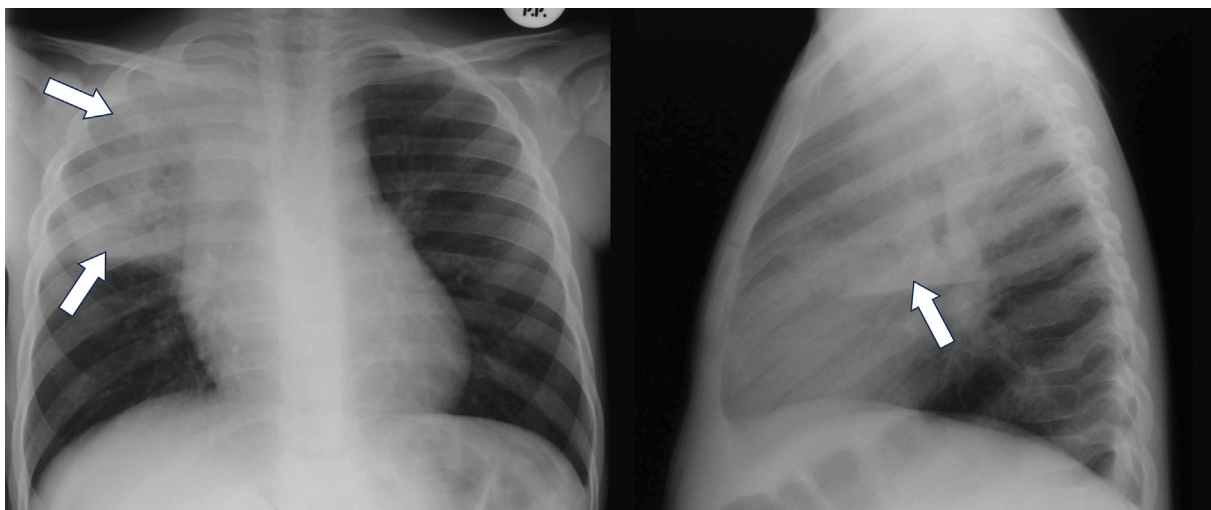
Frontal and lateral chest radiographs of an 8-year-old malnourished male patient with confirmed TB, who was HIV-positive, demonstrating right upper lobe airspace consolidation (arrows) with air bronchograms.
